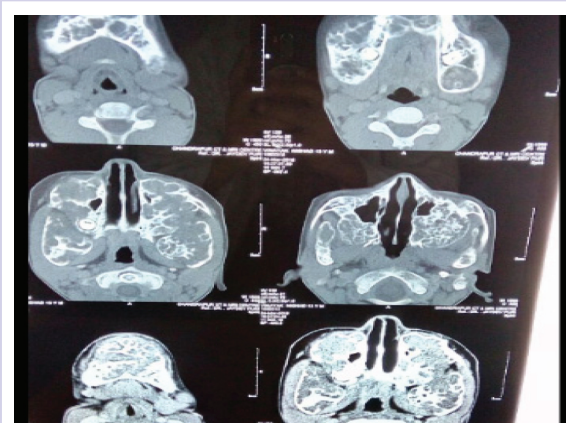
Computed tomographic images showing osteolytic lesions in mandible and maxilla
